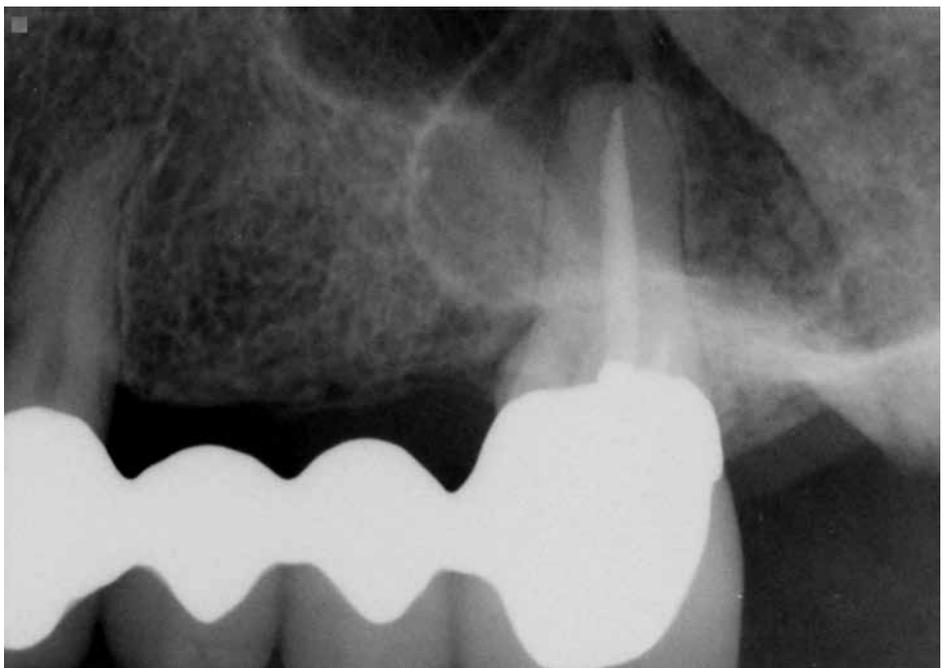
Radiograph at 7-month recall demonstrating good bone-fill at the resected and grafted mesial buccal root area
